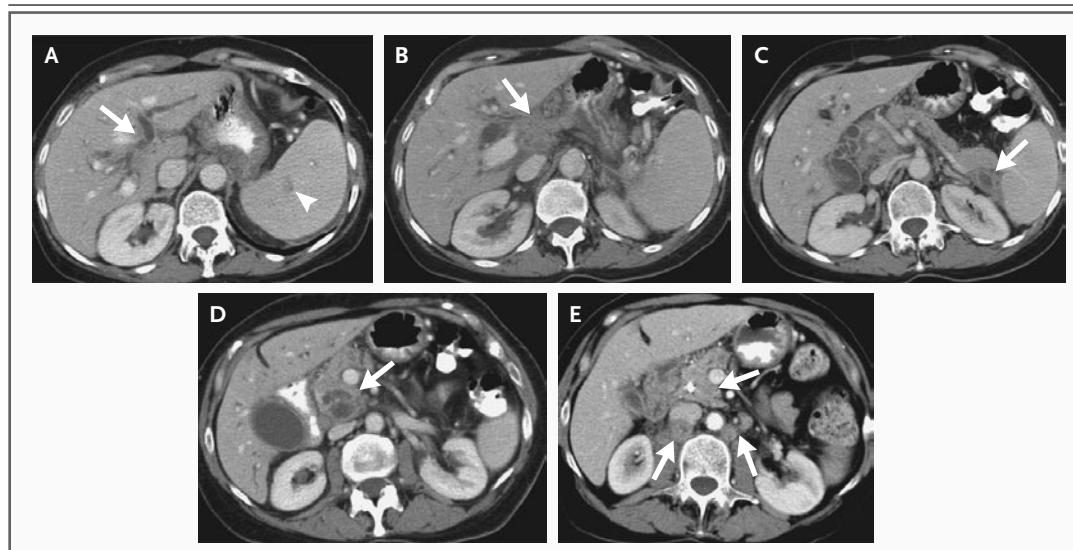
Contrast-Enhanced CT Images of the Abdomen.
